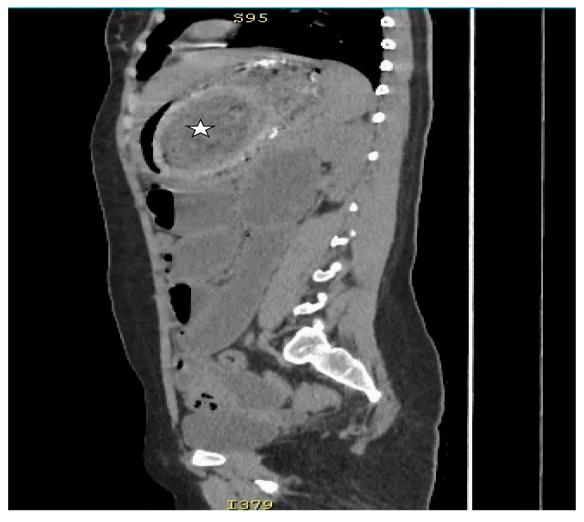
CT coronal view showing a bezoar in the stomach as outlined by contrast (star).
